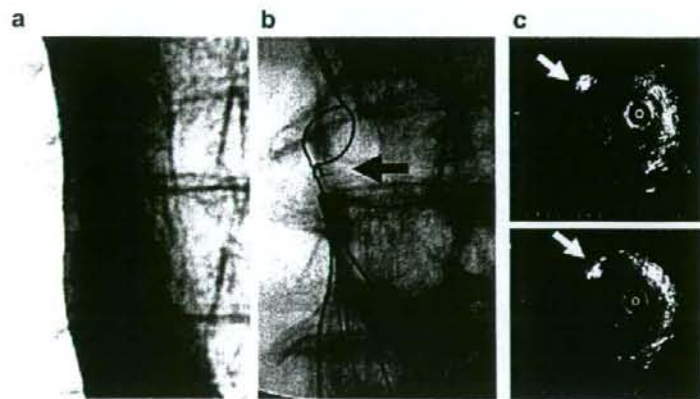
Images from a 78-year-old man with documented massive pulmonary thromboembolism and lower extremity deep vein thrombosis who underwent successful insertion of a Günther Tulip Filter (GTF) and thrombolytic therapy. After the thrombus disappeared, removal of the GTF failed. (a) Vena cavogram shows the hook of the GTF attached to the vein wall at 10°. (b) The loop-wire cannot snare the hook. (c) The intravenous ultrasound image shows the GTF hook attached to the inferior vena cava wall, and a high-intensity echogram shows supposed fibrin deposits around the hook.
